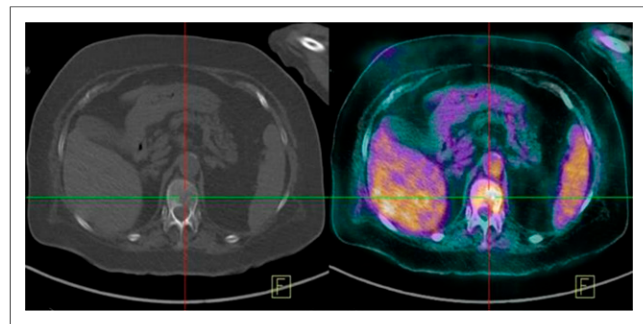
PET/CT images of case of spondylodiskitis.
